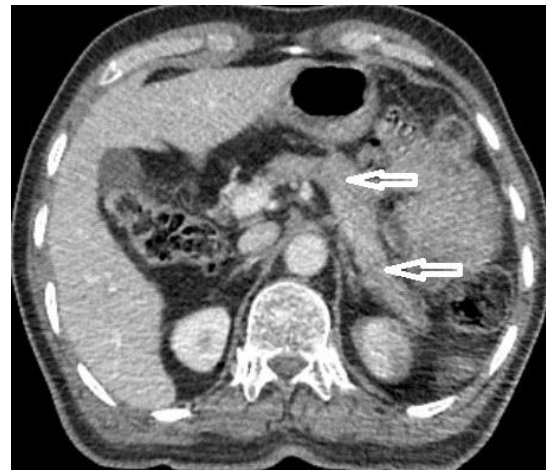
Axial computed tomography scan, normal looking pancreas gland with no pathology (White arrows)
